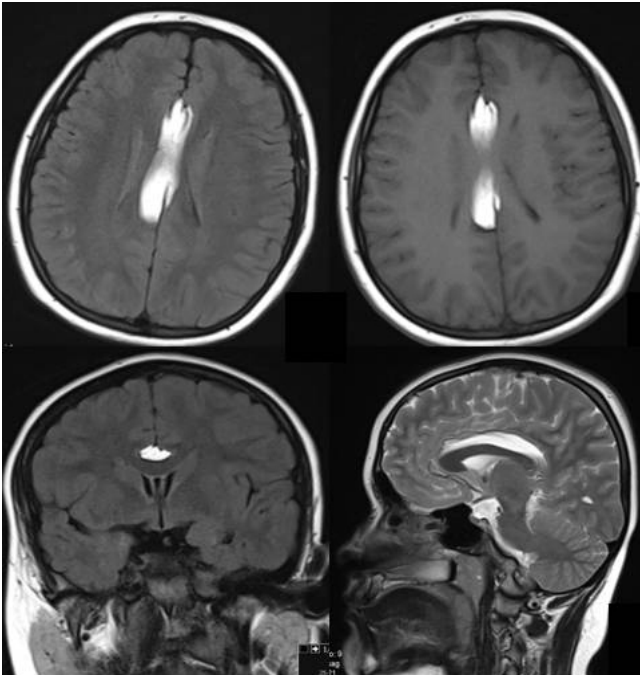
T1-weighted axial/coronal, and T2-weighted sagittal sections show hyperintense, approximately 6,5 x 1,2 cm lipoma around corpus callosum
